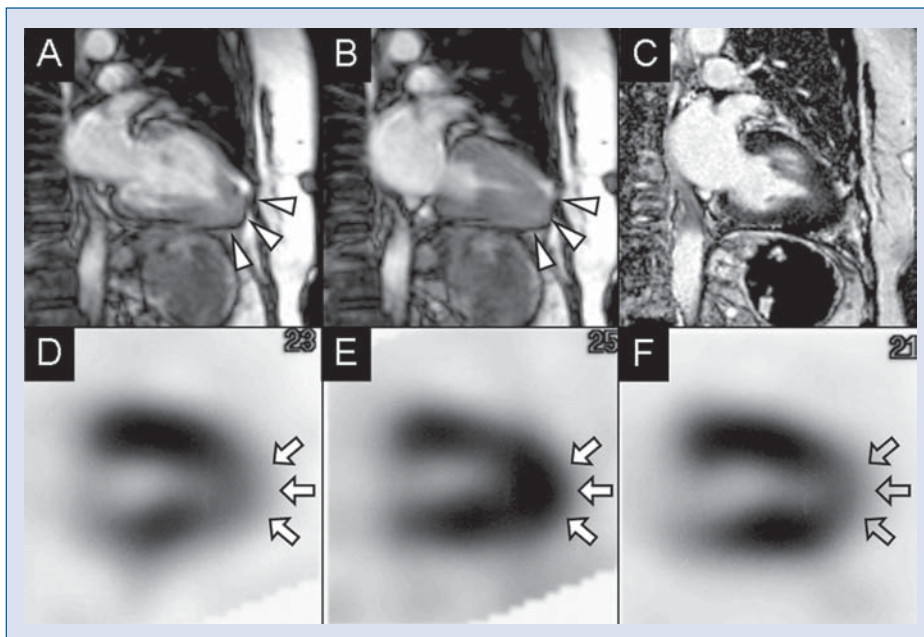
Cardiac magnetic resonance imaging cine images at diastole (A) and at systole (B) confirm left ventricular apical myocardial hypertrophy with normal wall motion (solid arrowheads). Gadolinium late enhancement image (C) shows no hyperintense areas. ²⁰¹TlCI image at early phase (D) shows area of significantly decreased uptake in left ventricular apical myocardium, and ²⁰¹TlCI image at late phase (E) shows complete redistribution (solid arrows). ¹²³I-BMIPP image at early phase (F) shows area of significantly decreased uptake in apical myocardium (unfilled arrows).
